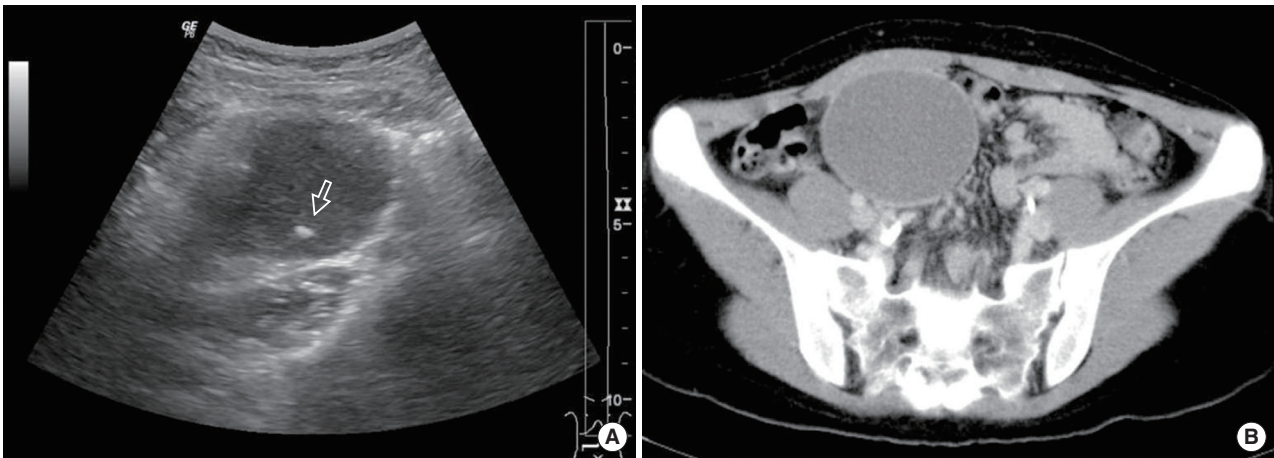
Radiologic findings. (A) A hypoechoic mass with an echogenic dot (arrow) in the right lower quadrant is observed on ultrasonography. (B) A cystic mass with linear calcification in the mesentery adjacent to the ascending colon is observed on computed tomography.
